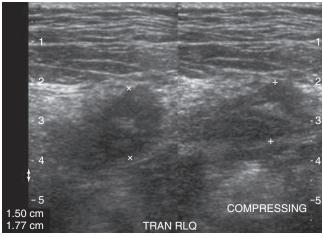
Sonogram of the right lower quadrant.
